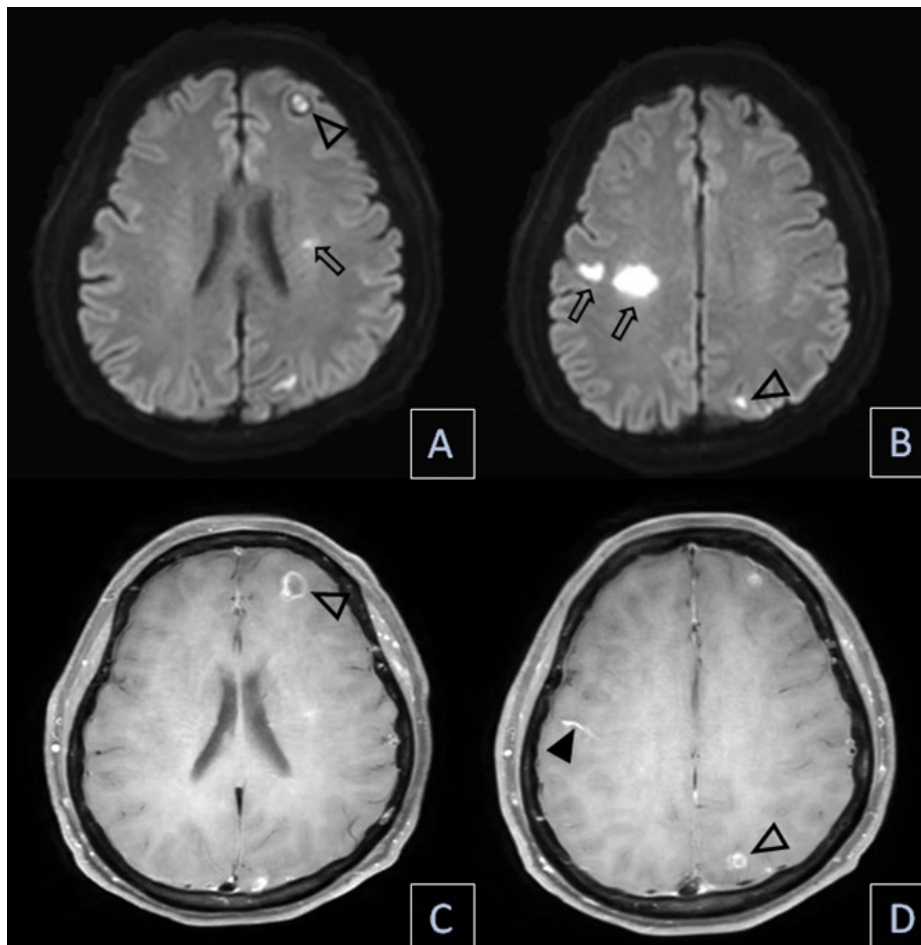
A 54-year-old-female underlied moderate to severe MR with infective mitral endocarditis. Axial MRI diffusion-weighted images (A and B) and post-contrast T1 weighted images (C and D) show two small rim enhancing microabscesses in the left frontal lobe and the left parietal lobe (open black arrowheads), a few small acute infarctions in the left corona radiata and the right centrum semiovale (open black arrow), and meningeal enhancement in the right frontal sulci (solid black arrowhead).
